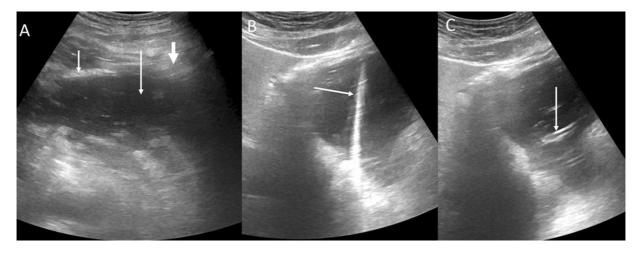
(A) Ultrasound image shows a collection in the lesser sac (arrow). Note the stomach (short arrow) covering part of the collection. Thick arrow points to the omentum. (B) The collection was accessed via transperitoneal route with guidewire in place (arrow). (C) A catheter has been placed within the collection (arrow).
